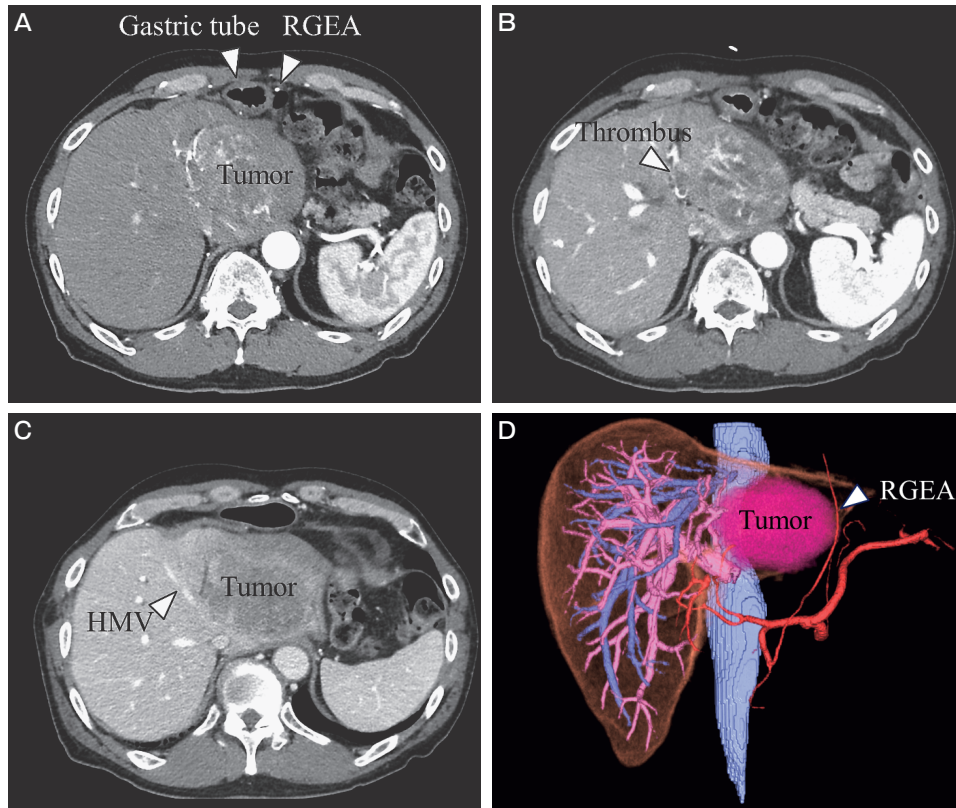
Contrast-enhanced computed tomography images. (A), The well-enhanced tumor in the arterial phase. The gastric tube running through the retrosternal pathway and the right gastroepiploic artery (RGEA) are confirmed; (B), The enhancement pattern of the portal phase revealing the tumor thrombus protruding into the left portal vein; (C), The enhancement pattern of the venous phase showing rapid washout. The middle hepatic vein is compressed by the tumor; (D), The relationship between the tumor and the RGEA based on three-dimensional imaging.
